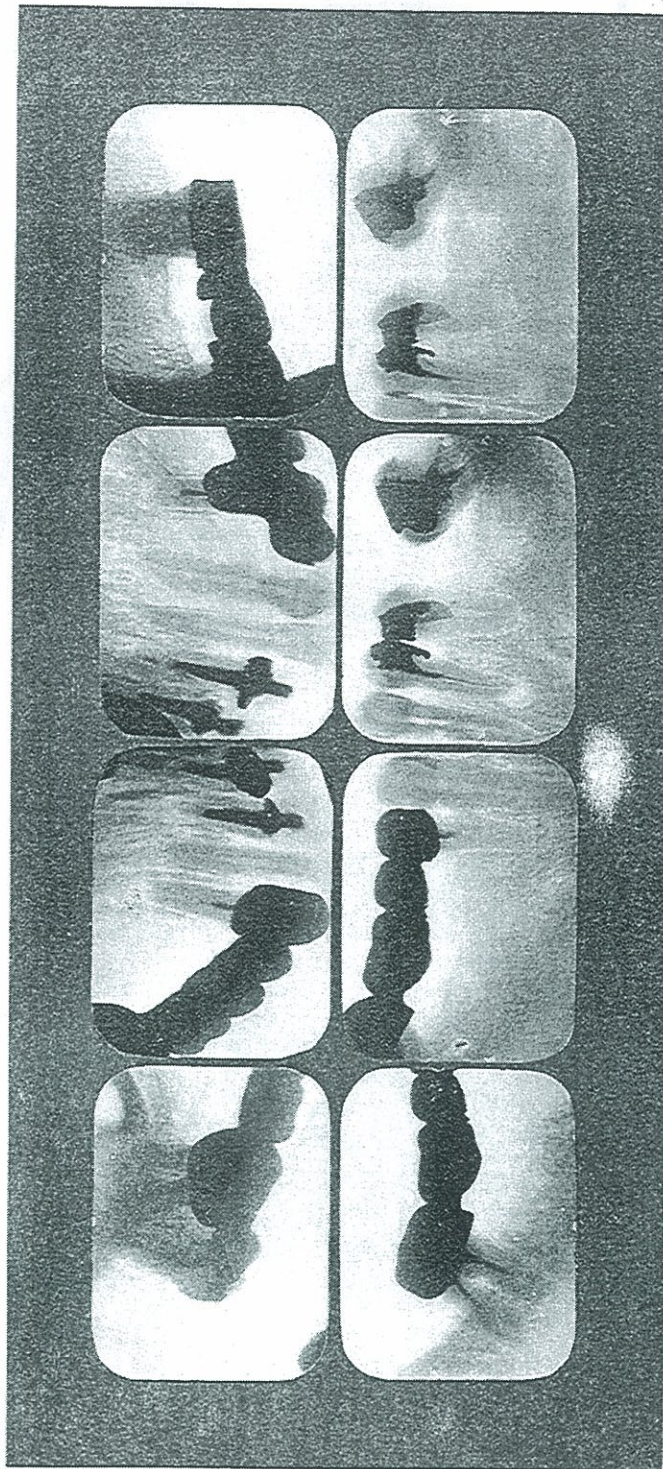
ROENTGENOGRAPHIC APPEARANCE OF DENTAL CONDITIONS OF CASE NO. 1057, SUFFERING FROM SEVERE ACIDOSIS, WITH HEART, STOMACH, AND RHEUMATIC INVOLVEMENTS.
